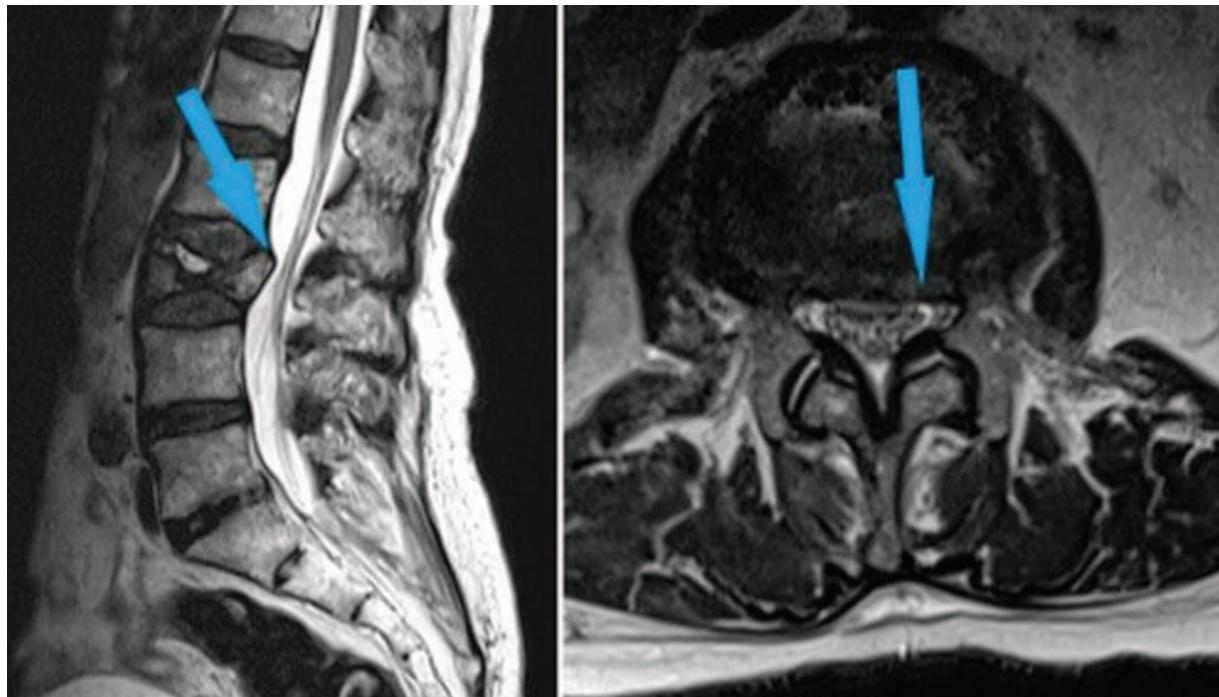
Preoperative MRI (sagittal T2-axial T2) (blue arrows).
